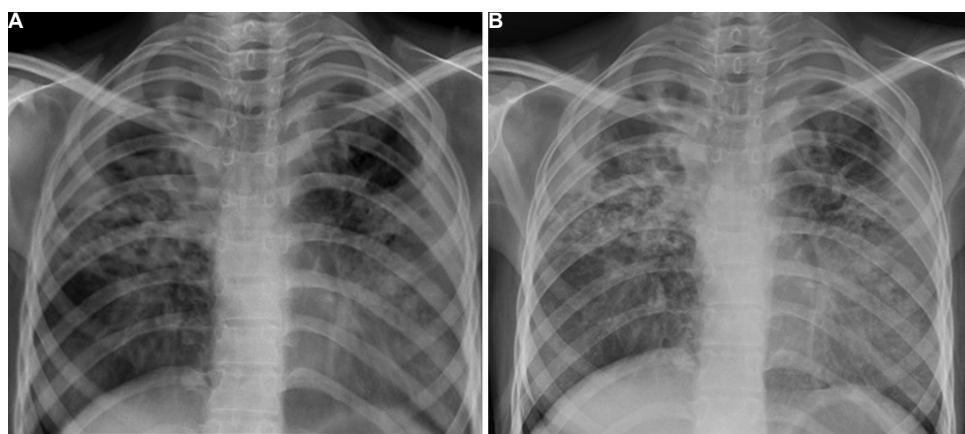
Chest X-ray images for the same individual with evidence of disease using (A) mine 2 machine, and (B) digital X-ray machine.
